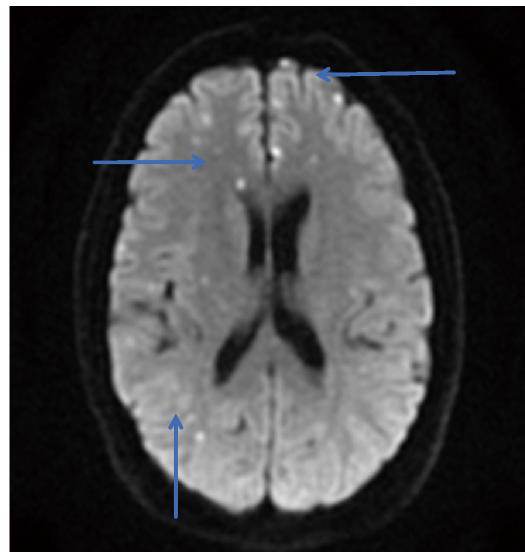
MRI-DWI sequence of asymptomatic cerebral infarction. Blue arrows indicate regions of restricted diffusion associated with silent cerebral infarction, as identified on ADC mapping. DWI, diffusion weighted imaging.
